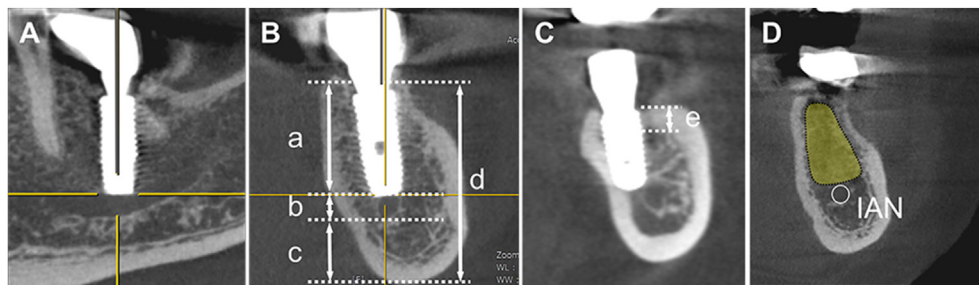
Radiographic measurements (A) Setting up the evaluation computed tomography view parallel to the long axis and passing through the center of the implant (B, C) Linear measurements for the mandible. The measurements are as follows: (a) distance from the alveolar crest to the superior aspect of the inferior alveolar nerve (IAN); (b) vertical height of the IAN; (c) distance from the inferior aspect of the IAN to the mandibular inferior border; (d) total mandibular height; (e) cortical thickness (D) Measurement of bone density. The bone marrow area superior to the IAN was designated as the region of interest, and the bone density within this selected area was measured in Hounsfield units.
